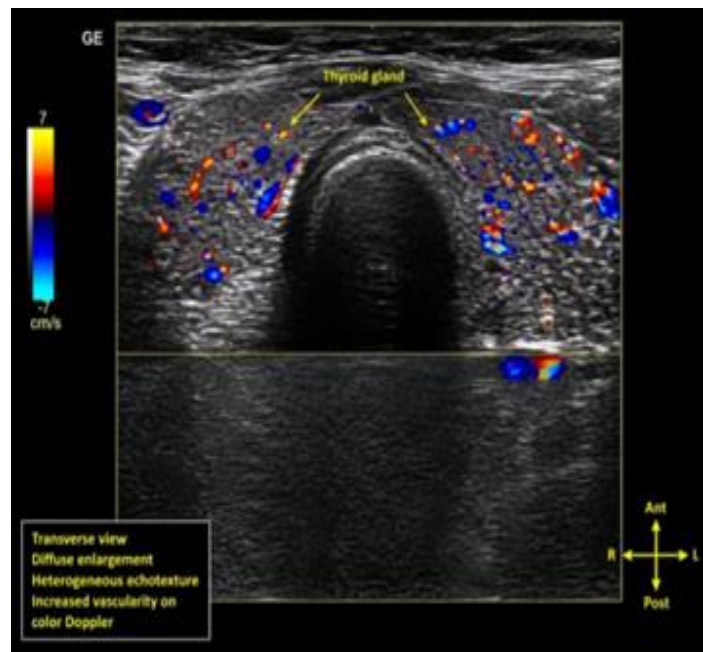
Color Doppler ultrasonography of the thyroid gland. Color Doppler ultrasonography demonstrating diffuse enlargement of the thyroid gland with heterogeneous echotexture and increased vascularity, suggestive of coexisting thyroiditis.
